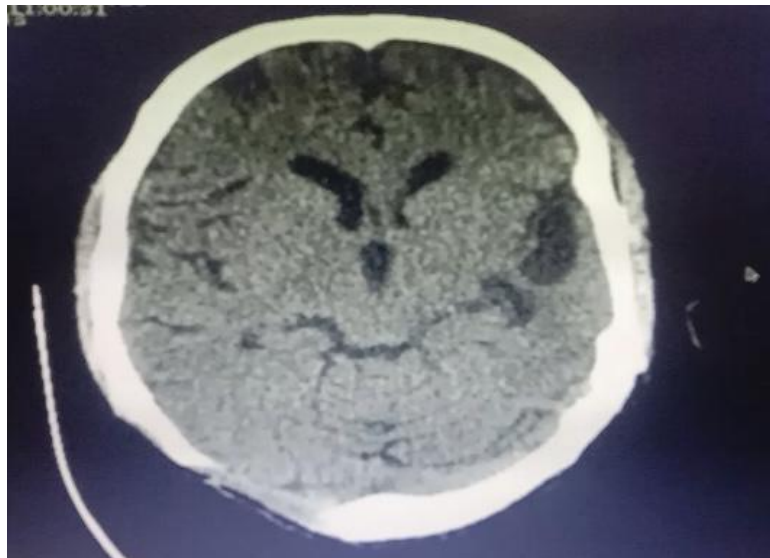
Follow up CT scan after 1 month
